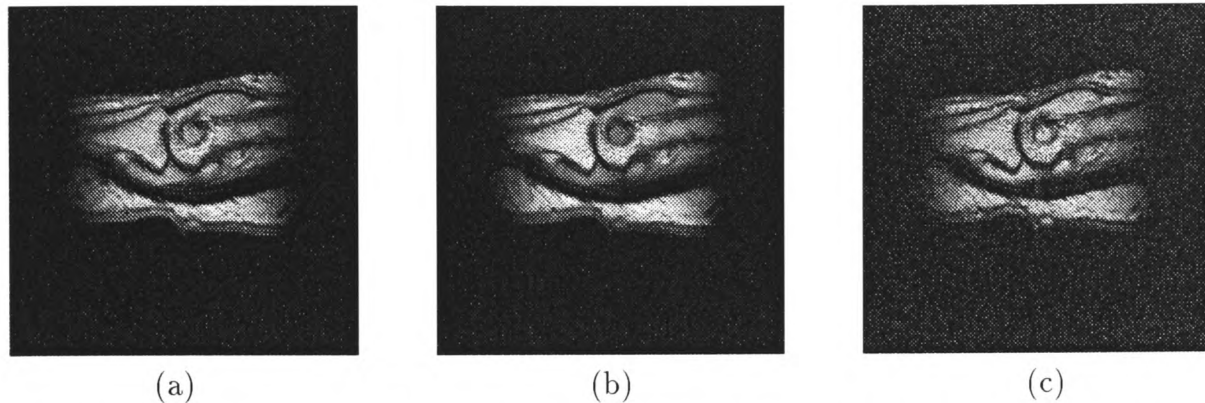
(a) PD-weighted image contrast stretched (b) T2-weighted image contrast stretched (c) T1-weighted image contrast stretched.
